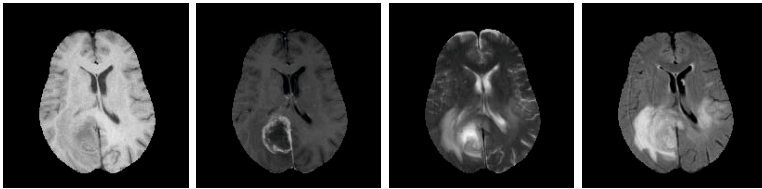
Axial slice of one patient. The four MRI modalities under study are shown, from left to right: the T_1 , T_{1c} , T_2 and T_{2f} image.
